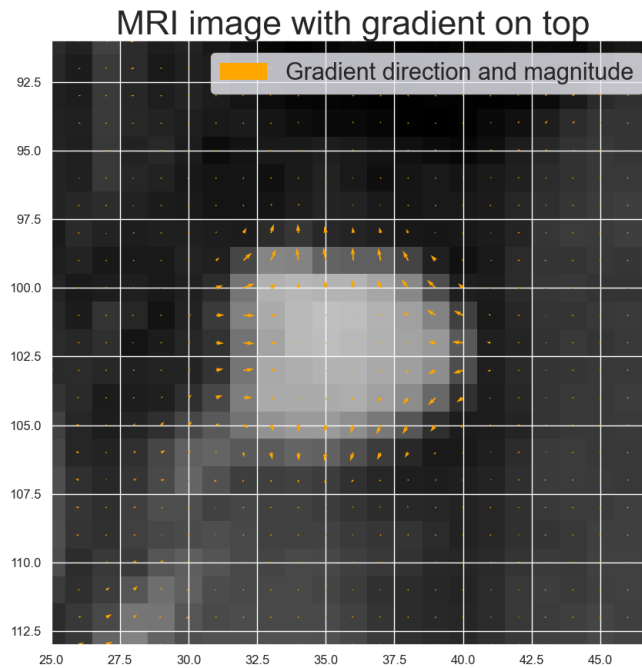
Representation of the gradient magnitude and direction on the MRI image of P1C at $t = 0.4$ s.
